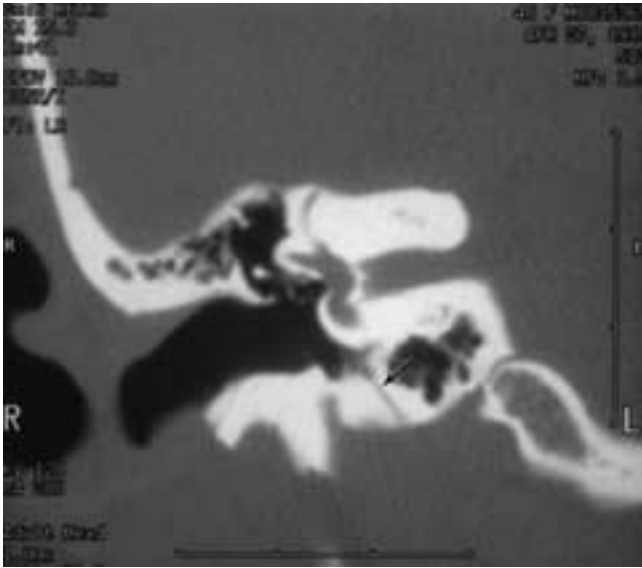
Pseudo-fracture, inferior tympanic canaliculus. Coronal CT image of the right ear demonstrates this vertically oriented structure (arrow).
